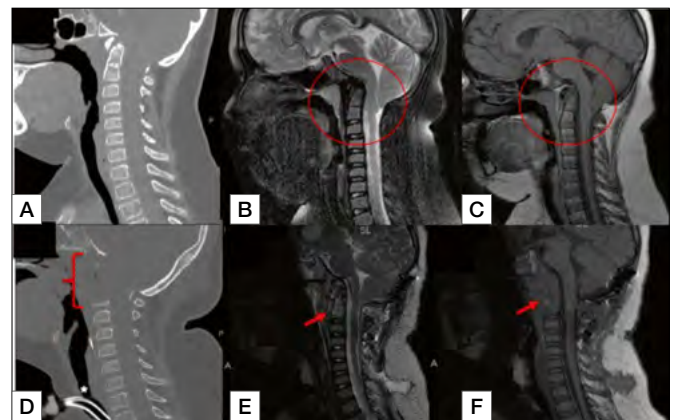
CT scan (A) and T2 (B) and T1(C) weighted MRI of a case of impressio basilaris and platybasia + bulbo-medullar compression (rounded area). This lesion was treated with transoral approach that allowed a wide exposure and resection from clivus to C1(†) and decompression (arrow) as showed in postoperative CT (D) and T2 (E) and T1(F) MRI, in which you can observe the presence of tracheostomy (*).
